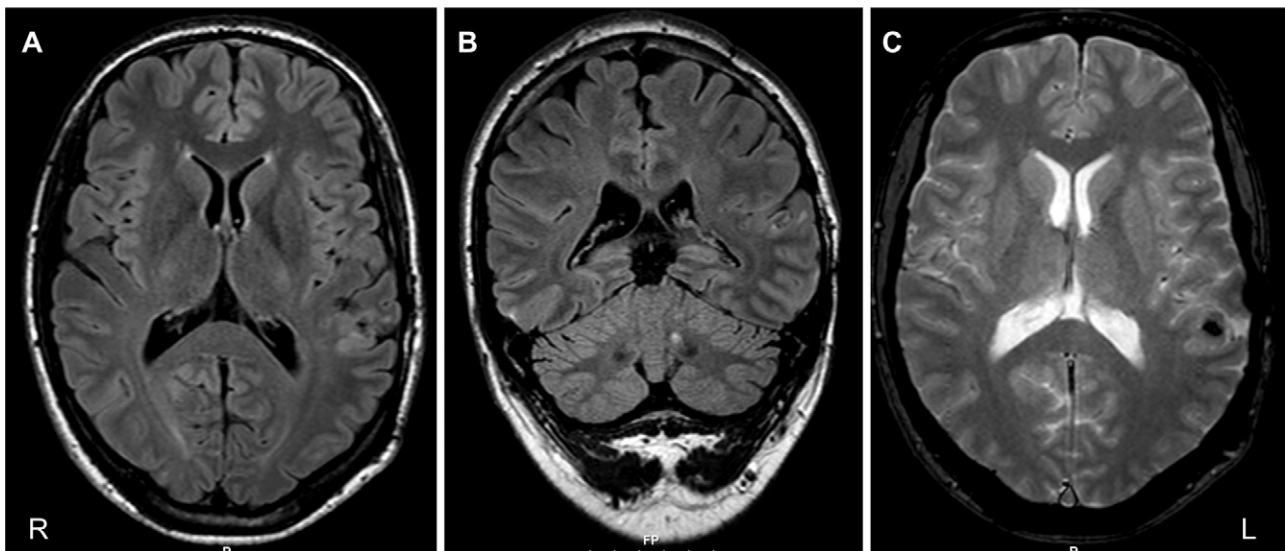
Preoperative T₁-weighted axial (A) and frontal (B) MRI scans to indicate small cortico-subcortical defect with reactive gliosis in the posterior part of the left superior temporal lobe corresponding to residuum of the first biopsy procedure nearly twenty years ago. Note lack of evidence of a space-occupying process. (C) T₂-weighted sequence corresponding to section plane depicted in (A) shows discreet secondary enlargement of subarachnoid space over the previous biopsy site. No perifocal edema is apparent. L, left; R, right.
